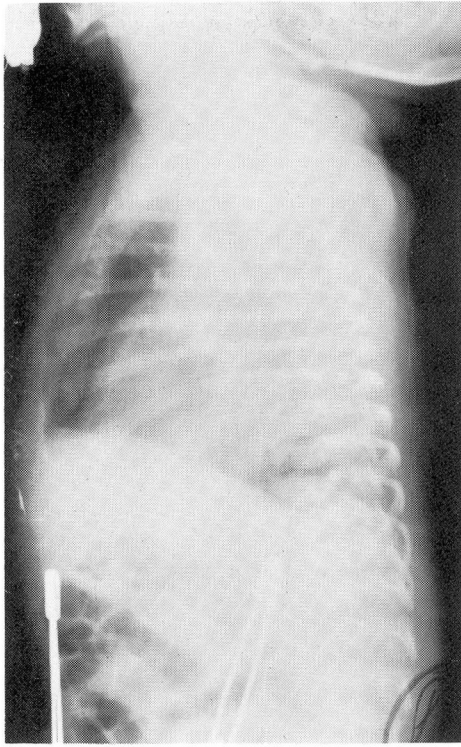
Case 2. Lateral roentgenogram of the chest, demonstrating herniation of the right middle lobe in the anterior mediastinum.
